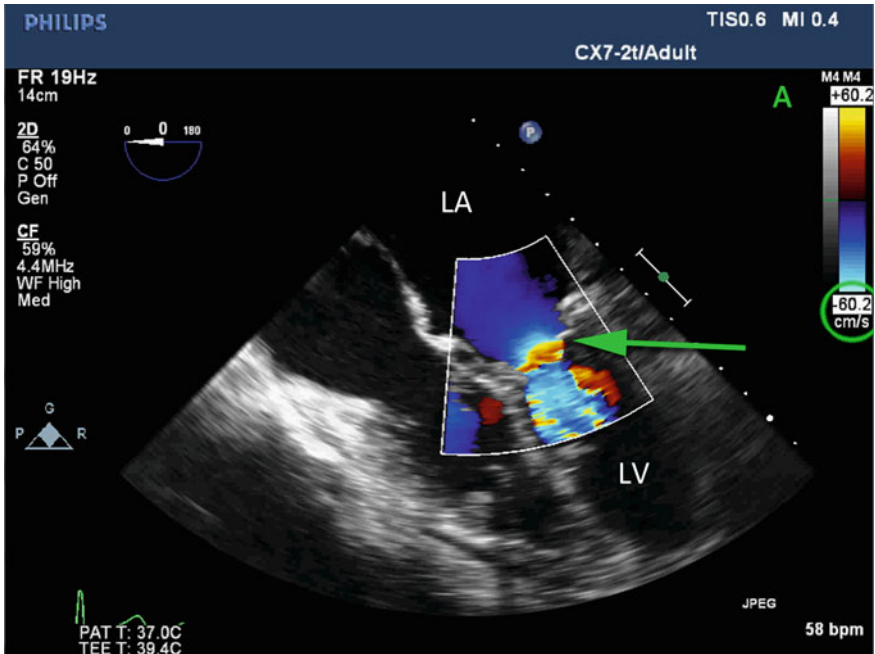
Midesophageal four-chamber view with transmitral color flow Doppler demonstrating aliasing. The flow map (A) indicates that flow away from the probe is *blue*, flow toward the probe is *yellow*, and the limit below which aliasing does not occur is 60.2 cm/sec. The *arrow* shows an aliasing line, where flow exceeds 60.2 cm/sec, and downward flow turns from *blue* to *yellow*. LA left atrium; LV left ventricle
